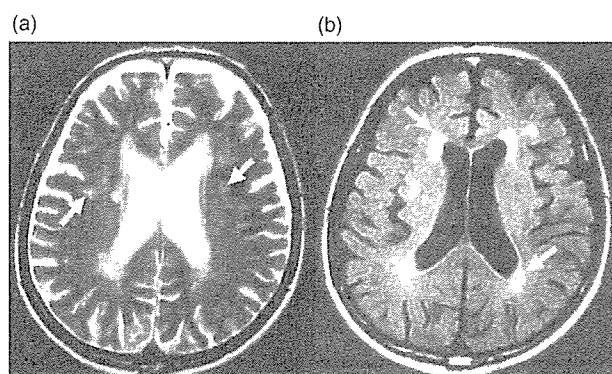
An example of subcortical (a) and periventricular (b) white matter hyperintensities on brain MR imaging
